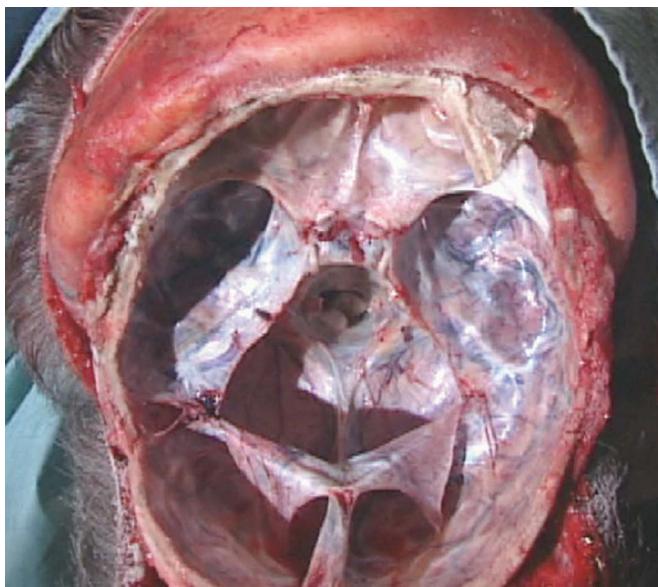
Base of the skull. The skull is seen with the dura attached. The dura is then peeled off to check the base of the skull for fractures. Direct examination of the base of the skull for fractures is often more effective than radiographs.
